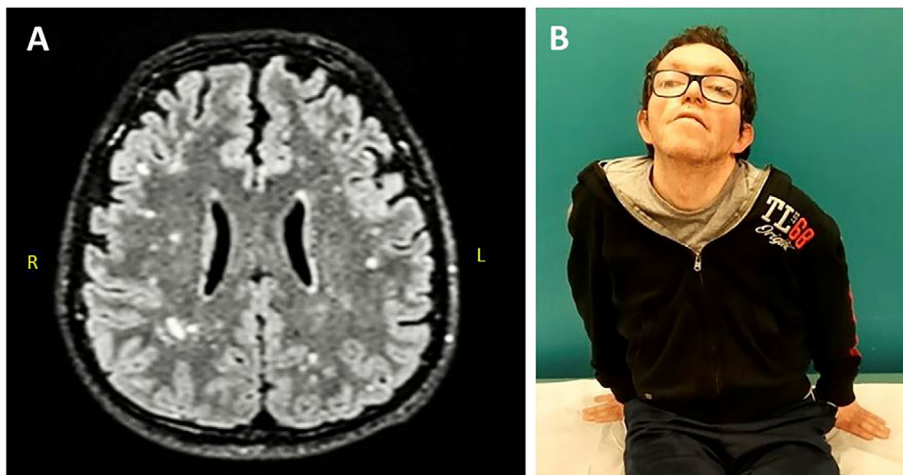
(A) Patient's MRI, T2-FLAIR weighted sequence, axial slice, revealing diffuse white matter lesions. (B) Patient's photograph revealing typical dysmorphic features (ie, hypertelorism, protruding ears, ptosis), cervical dystonia and dystonic posture of the arms.
